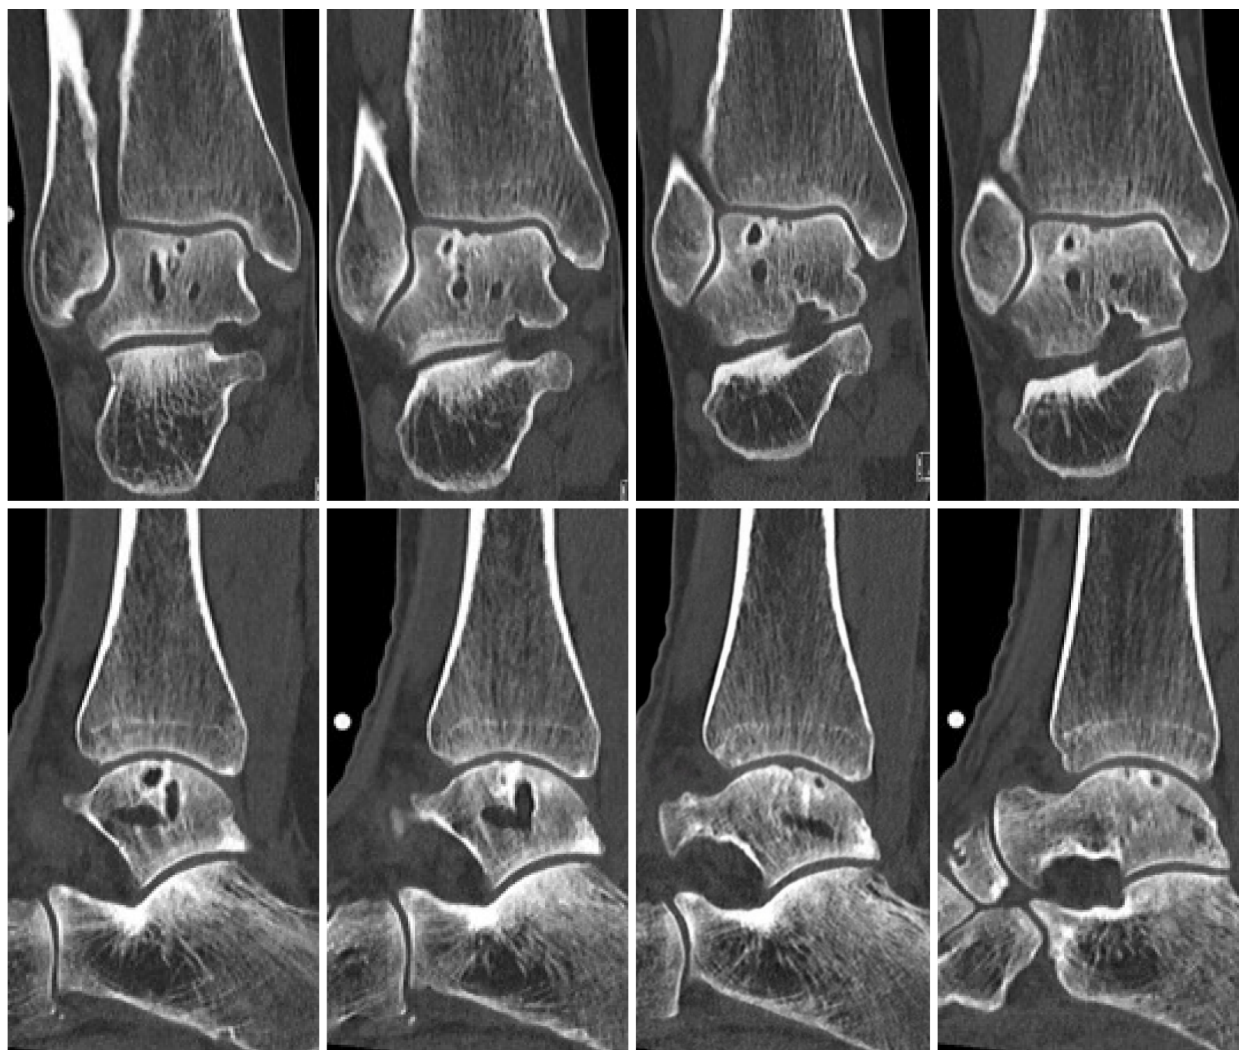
Pre-operative computed tomography scan of patient number 2: Upper part shows coronal slides with the images from left to right going into the posterior to anterior direction. The lower part shows sagittal slides with the images from left to right going from lateral to medial.
